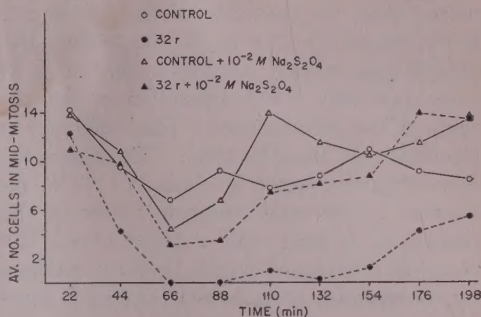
Effects of X-rays on mitotic activity of grasshopper neuroblasts in untreated and pretreated cultures.
